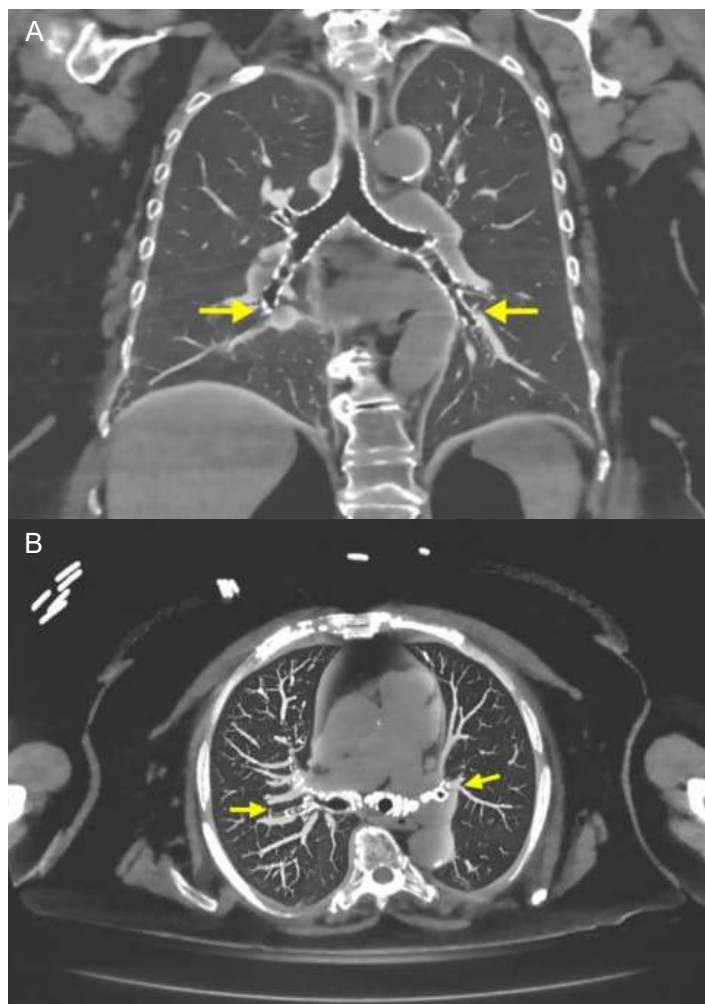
A) Coronal and B) axial contrast-enhanced computed tomography demonstrating branching hyperattenuating cement emboli within bilateral subsegmental pulmonary arteries (arrows).
